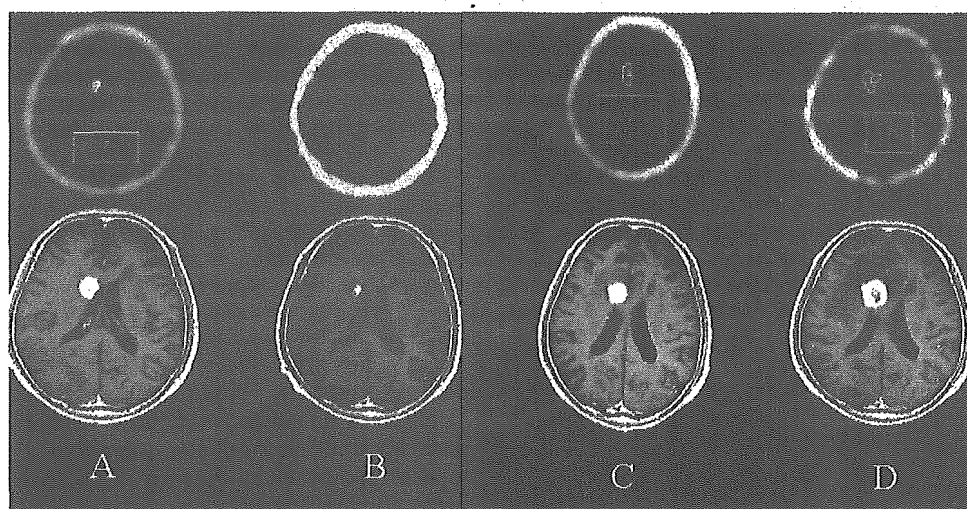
Serial enhanced MR image and ²⁰¹Tl SPECT studies obtained in the patient in Case 2. A: Pre-GKS: a metastatic lesion in the right caudate from lung adenocarcinoma. The pre-GKS TI index was 4.63. B: Two months later the tumor shows marked shrinkage. There is no abnormal TI accumulation. C: Six months later MR imaging demonstrated tumor regrowth, but the TI index remains low (3.08), necessitating serial measurements. D: Eight months later the area of enhancement has again increased in size. The TI index remains low (3.43). The radioisotope diagnosis was radiation injury.
